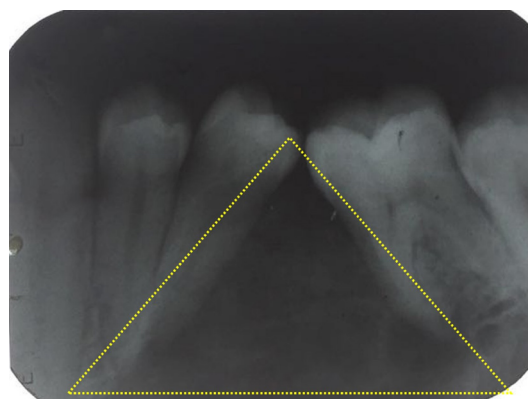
Periapical radiograph showing a well-defined mixed lesion, primarily radio-opaque, related to teeth #34, #35 and #36, extending from the distal aspect of #34 to the mesial aspect of #36. Loss of lamina dura was noticed distal to #34 and mesial to #36.
